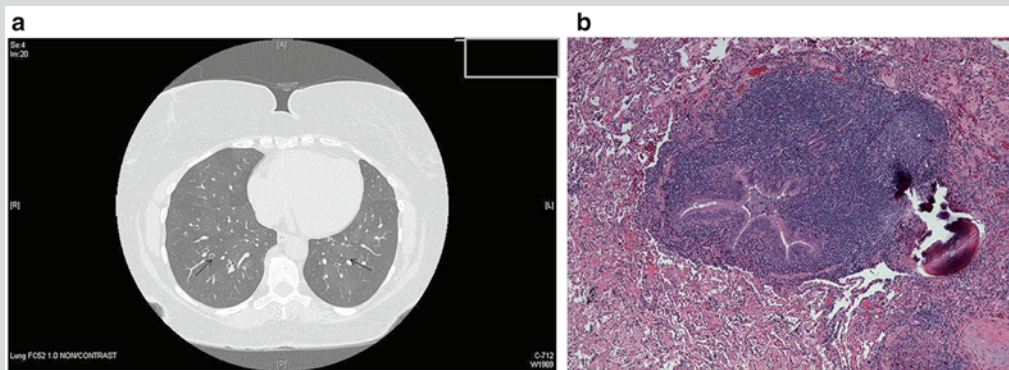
(a) Chest CT shows air trapping or mosaicism. (b) Lung biopsy confirms the presence of dense lymphoid follicles surrounding bronchioles
